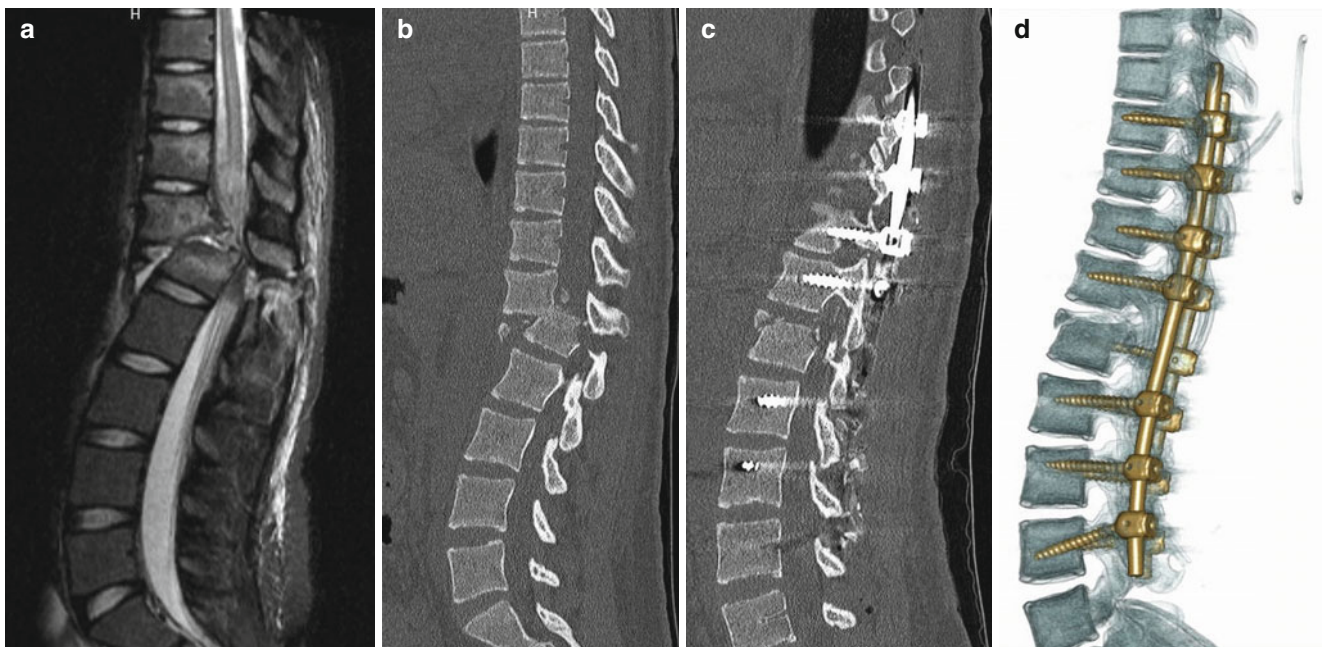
A 14-year-old female victim of an ATV accident. (a) Pre-op MRI. (b) Pre-op CT. (c) Post-op CT. (d) Post-op 3-D CT (Case courtesy of Eric J. Wall, MD)
